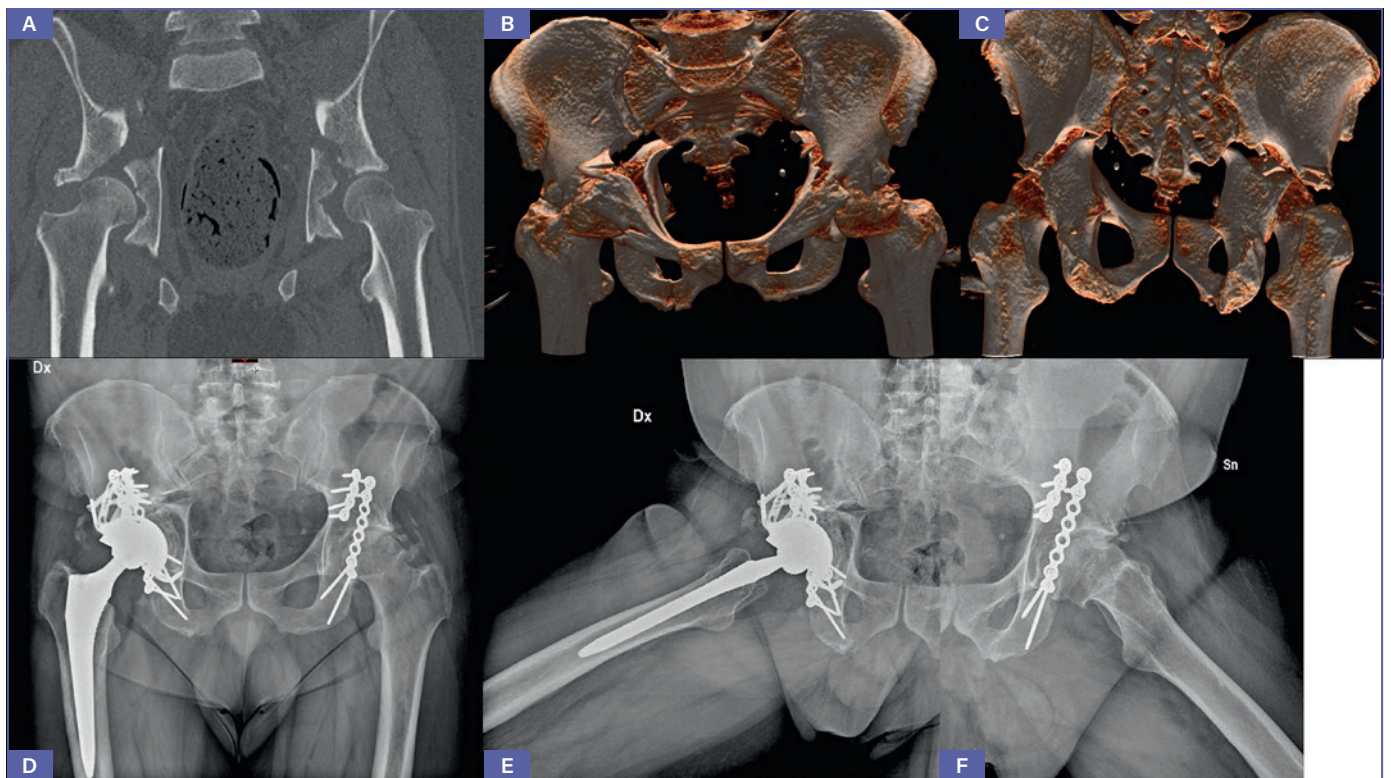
Bilateral acetabular fracture. A) Pre-operative frontal plane CT scan; B) Pre-operative 3D CT scan - anterior view; C) Pre-operative 3D CT scan - posterior view; D) Post-operative AP view X-rays showing posterior ORIF on the left side and posterior ORIF + Kerboul-plate + DM implant on the right side; E) Post-operative frog-leg view X-rays showing posterior acetabular ORIF + Kerboul-plate + DM implant on the right side; F) Post-operative frog-leg view X-rays showing posterior left acetabular ORIF.
